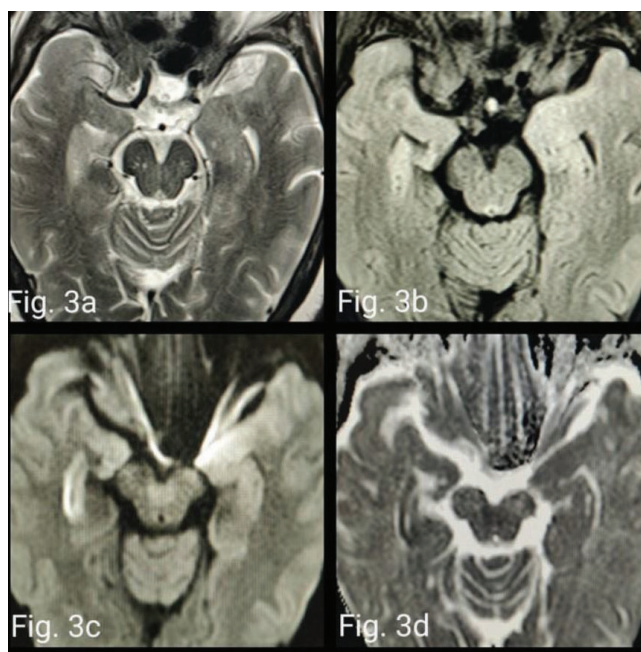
Axial T2W (a) and FLAIR (b) images show subtle asymmetrical hyperintensity in bilateral medial temporal lobes. DWI (c) and corresponding ADC (d) map show subtle diffusion restriction in bilateral temporal lobes.
